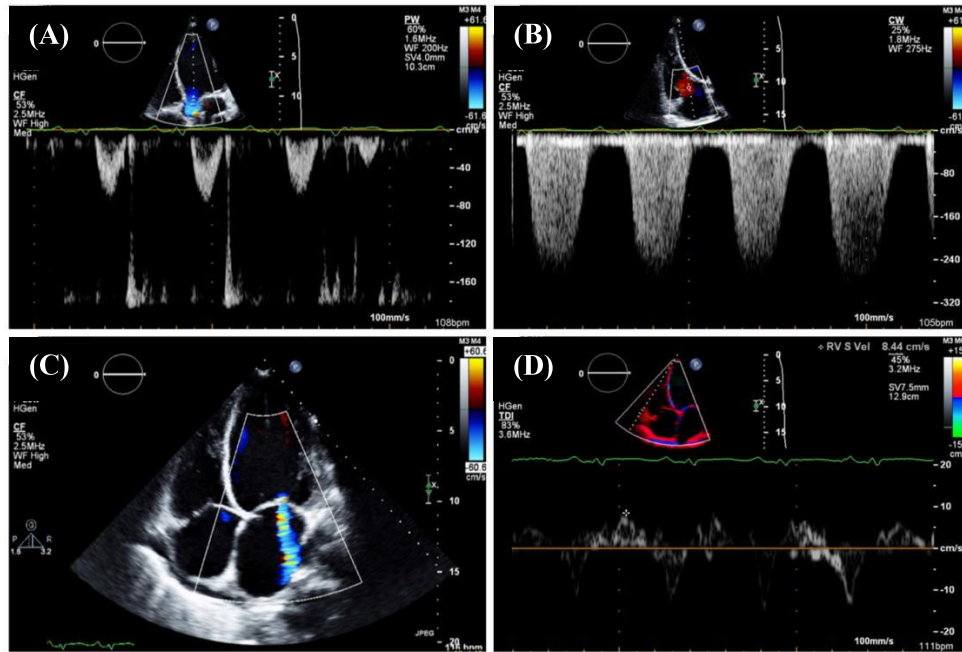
Doppler echocardiography: (A) Pulsed wave Doppler; (B) Continuous wave Doppler; (C) Color Doppler; and (D) Tissue Doppler Imaging (Sarullo, 2017)
